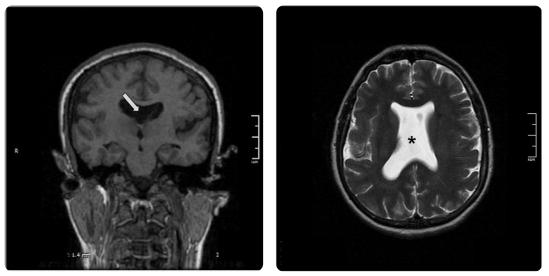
43-year-old female patient. Study for epilepsy control. a) Coronal MRI T1 3D SPGR: agenesis of septum pellucidum (arrow). b) Axial MRI T2 slice: agenesis of septum pellucidum (*).
